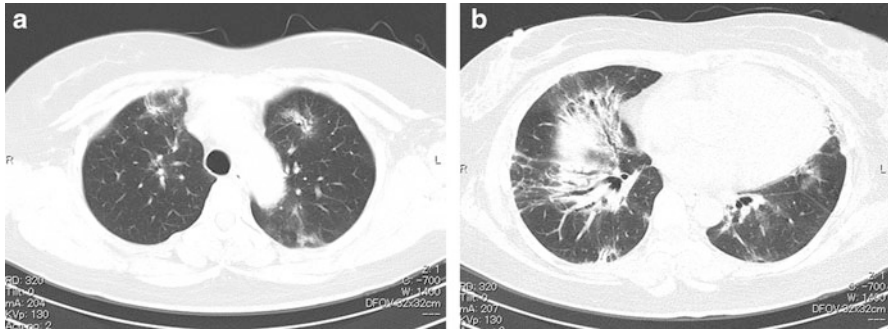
Interstitial pneumonia with collagen vascular disease (CVD-IP) (fibrosing nonspecific interstitial pneumonia [NSIP] pattern). (a, b) High-resolution computed tomography (HRCT) images show abnormal opacities located predominantly in the lower lungs that represent peribronchovascular ground-glass opacity and consolidation including traction bronchiectasis
